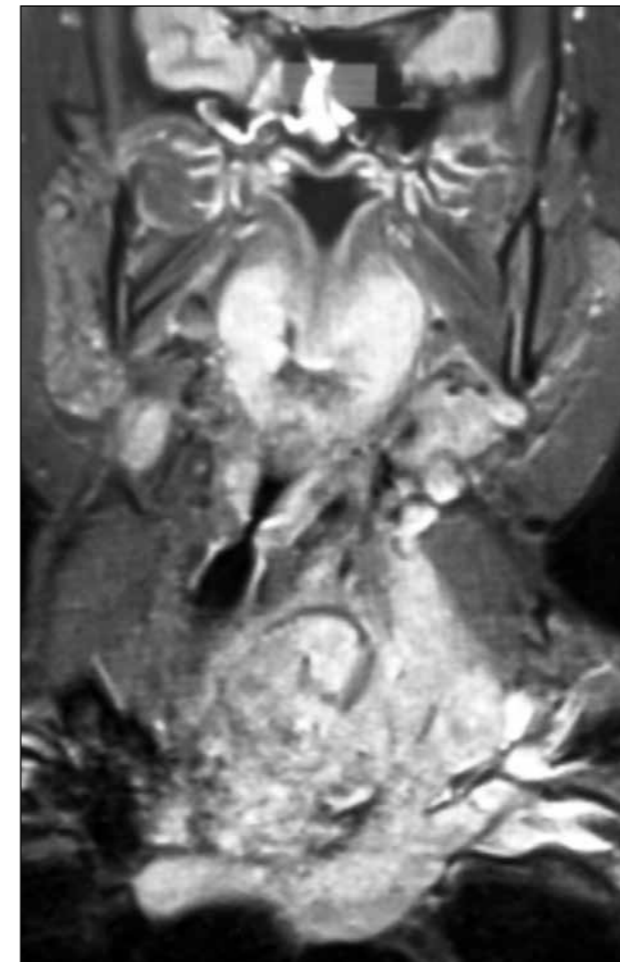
Contrast MRI coronal scan of a patient with a T4N1bM0 PDTCa with macroscopic invasion of the internal jugular vein.
